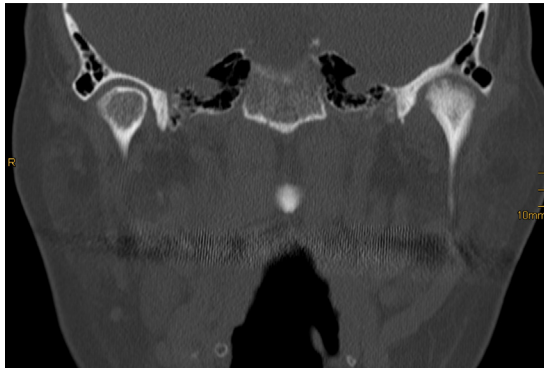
CT scan of the mandibular condyle obtained preoperatively.
